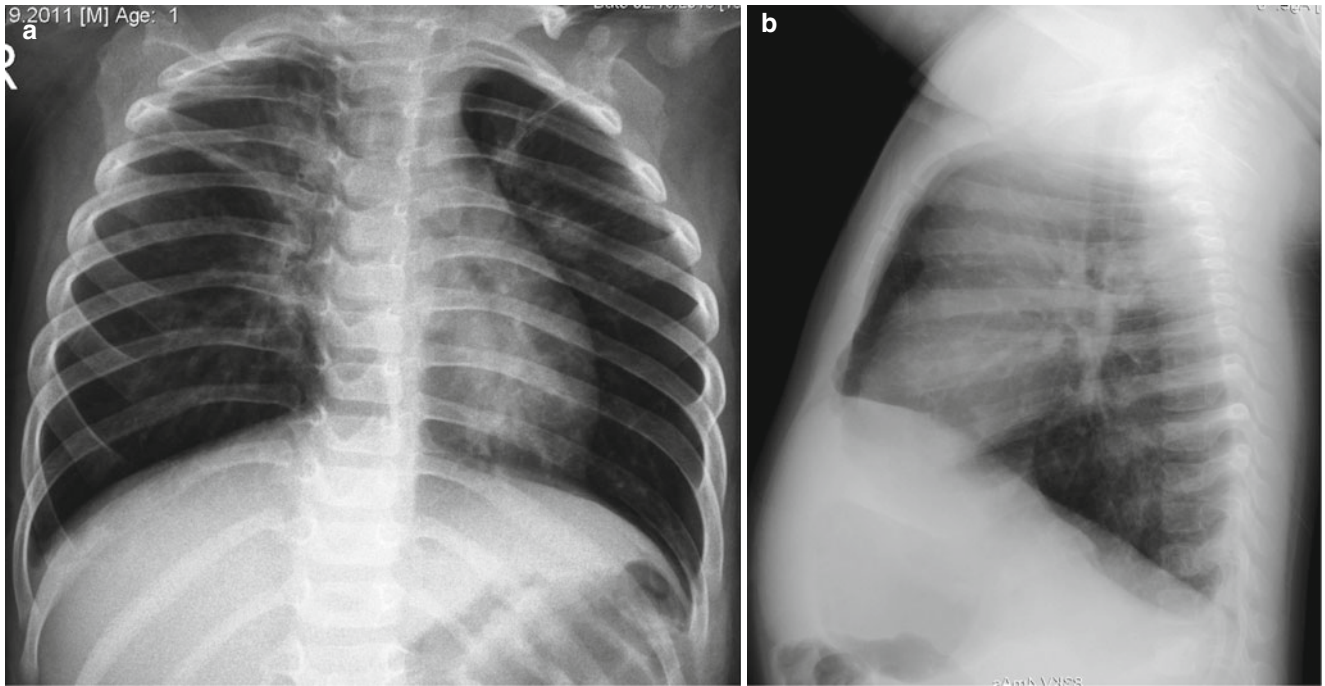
Respiratory syncytial virus (RSV) infection in an 18-month-old boy. Frontal (a) radiograph demonstrates hyperaeration, perihilar peribronchial thickening, and areas of subsegmental atelectasis. Lateral view (b) shows depression of the diaphragm compatible with hyperaeration
